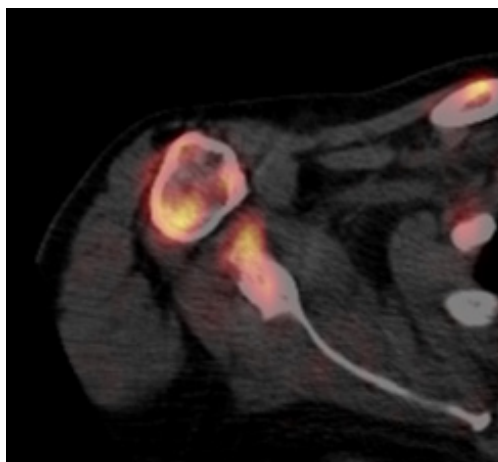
Same axial image as in fig. 3a showing diffuse increased uptake of radiotracer in PET/CT.
